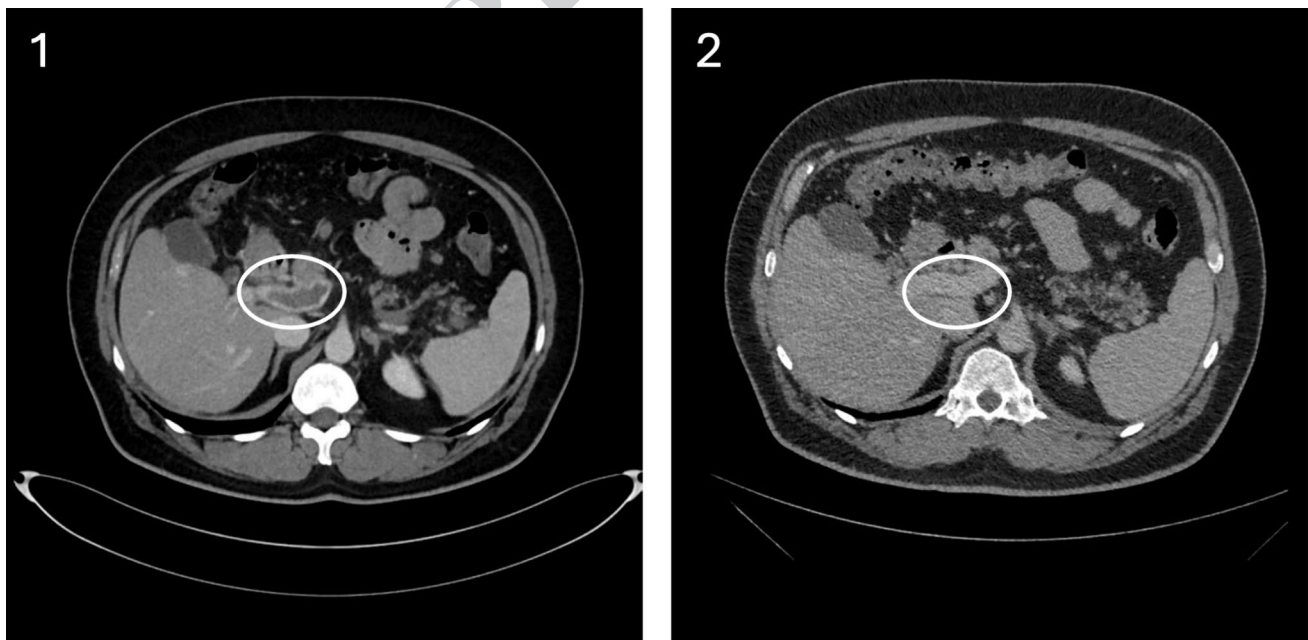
CT scan of the abdomen before (1) and after (2) anticoagulation, showing the nearly complete resolution of the portal vein thrombosis (circle)
